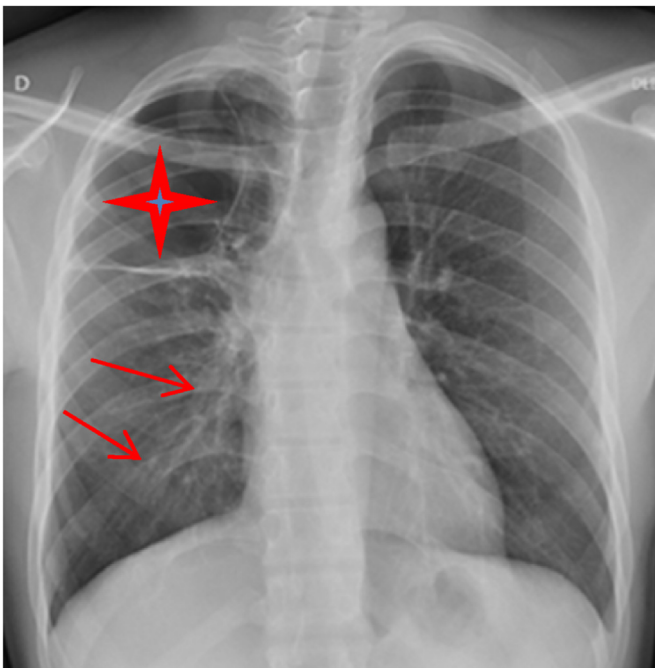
Face chest x-ray: Control at 12 months showing a large right apical bubble without sign of secondary infection (star), associated with a cylindrical dilation of the bronchi of the right middle and lower lobes (arrows).
